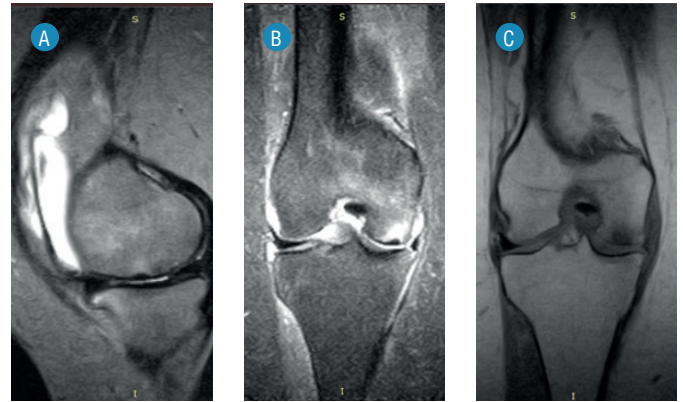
MRI of the right knee of patient B., 52 years old, with aseptic osteonecrosis of the medial femoral condyle, Ficat stage I, before treatment with regenerative technologies.
